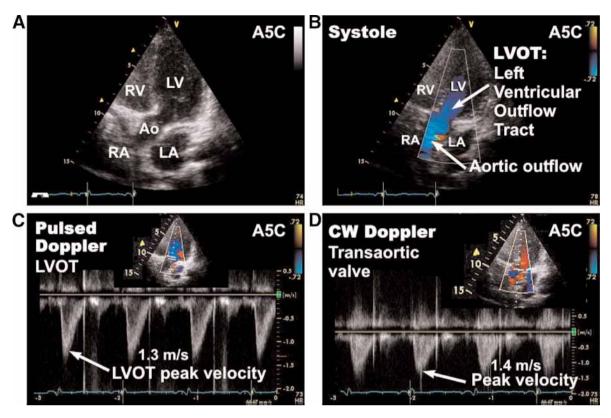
Apical five-chamber view (A5C).
